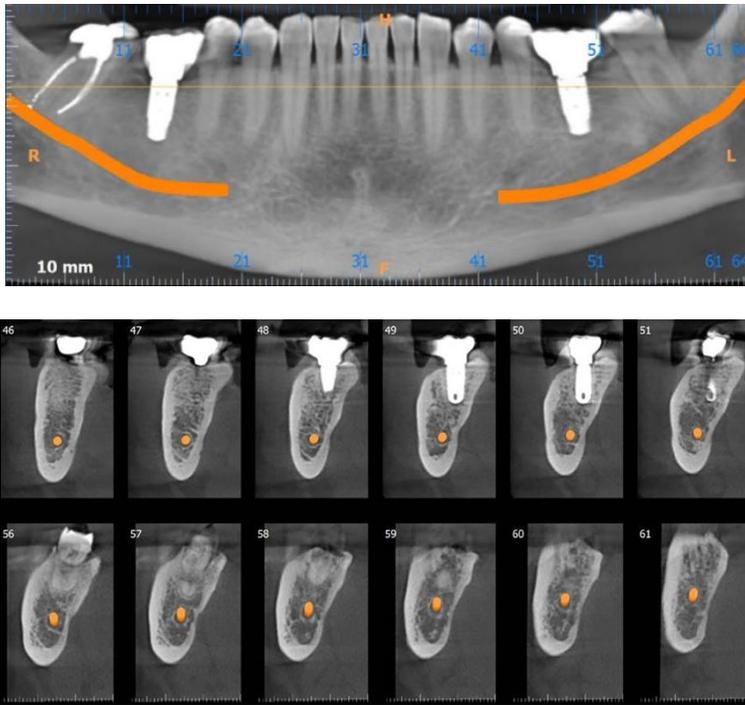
CBCT correlated to 37 where there is no presence of sequestrum.
